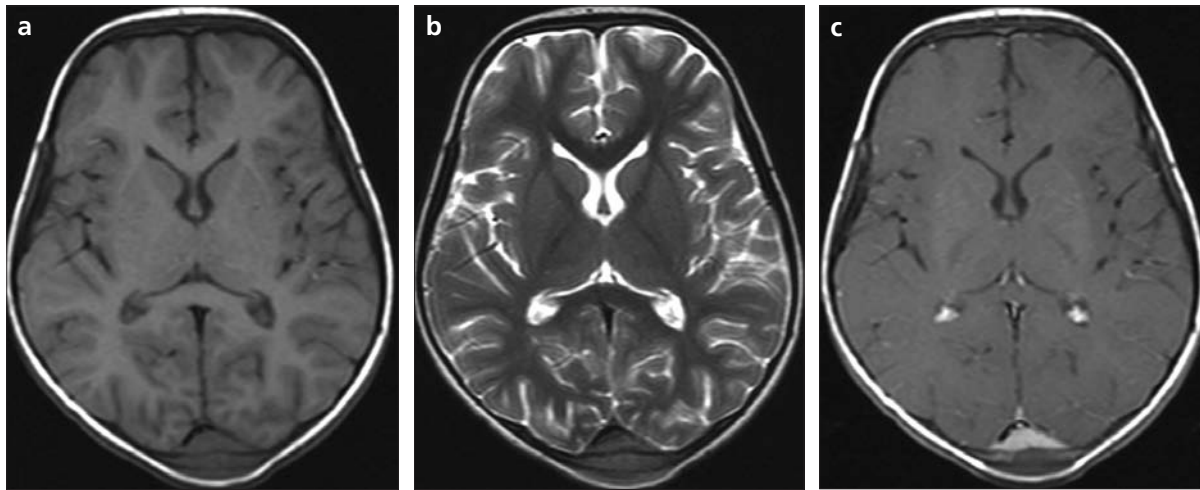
a–c. A 5-year-10-month-old girl with acute lymphoblastic leukemia and calvarial involvement. Cranial MRI shows a lesion in the dura, occipital bone, and scalp which was hypointense on T1- (a) and T2-weighted (b) images. There was enhancement in the dural and bony components of the lesion on contrast-enhanced axial T1-weighted images (c).
